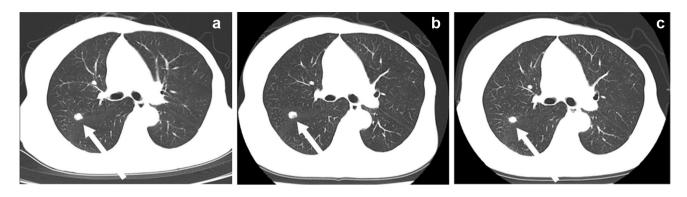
A 66-year-old woman with recurrent breast cancer (Case 1). A metastatic tumor $(10 \times 8 \text{ mm})$ in the upper lobe of the lung was detected by CT when tamoxifen therapy was stopped (a). Two months
